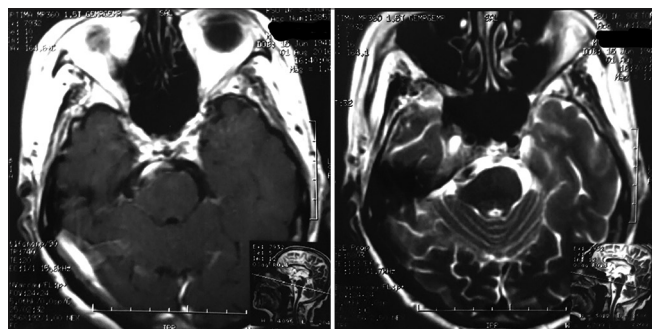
Noncontrast T1 and T2 magnetic resonance imaging
